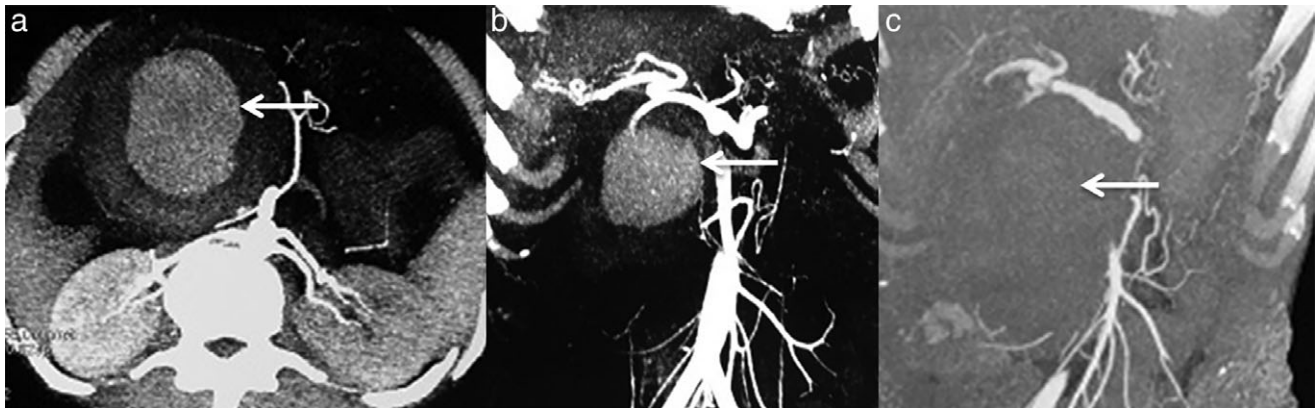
(a) CT angiography showing a large pseudoaneurysm (PSA); (b) axial image showing the PSA in relation to gastroduodenal artery (GDA); (c) postpercutaneous thrombin injection showing resolution of PSA.
